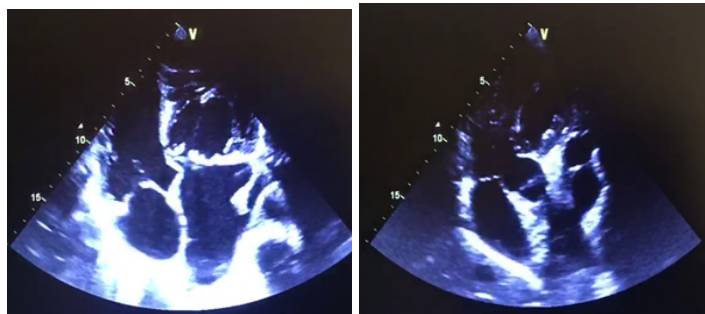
Transthoracic echocardiography apical 4 chambers (A) and 5 chambers (B) showing atrioventricular and ventriculo-arterial discordance.
